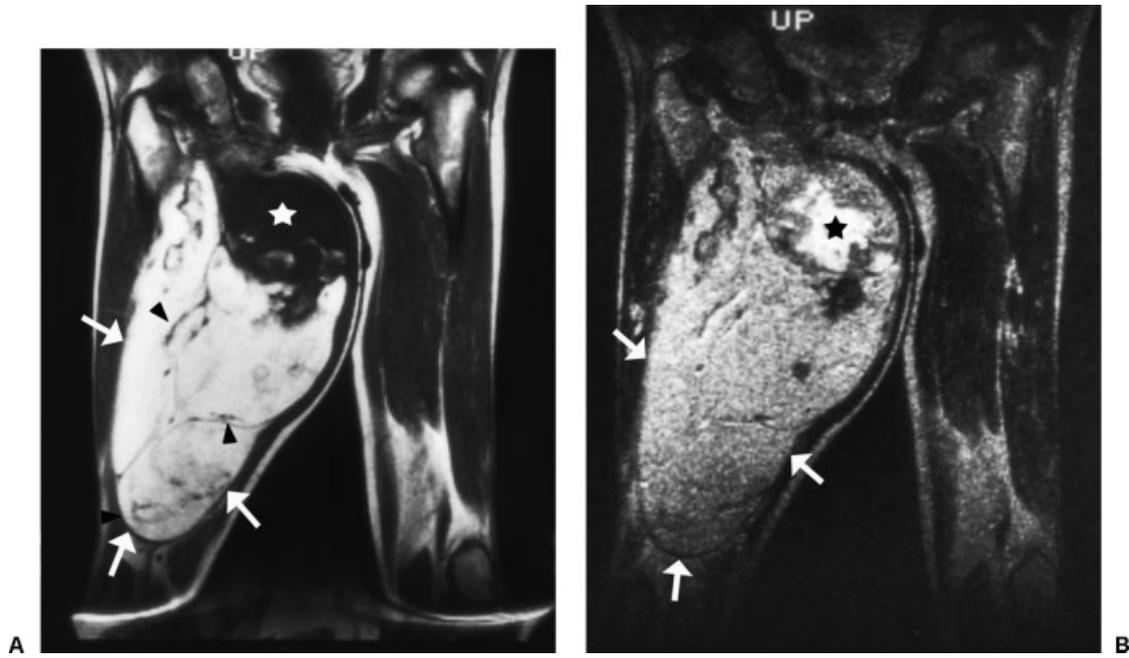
Dedifferentiated liposarcoma of the thigh in a 72-year-old man with a 10-year history of a slowly enlarging mass with more recent rapid growth. (A, B) Coronal T1-weighted (A, 500/16) and T2-weighted (B, 1600/120) MR images reveal a mass largely composed of tissue isointense to subcutaneous fat (arrows) but also containing thick septae (arrowheads). There is also a large nodular nonlipomatous component with nonspecific characteristics of low signal intensity on T1 weighting and heterogeneous intermediate to high signal intensity on T2 weighting superiorly (asterisks).
